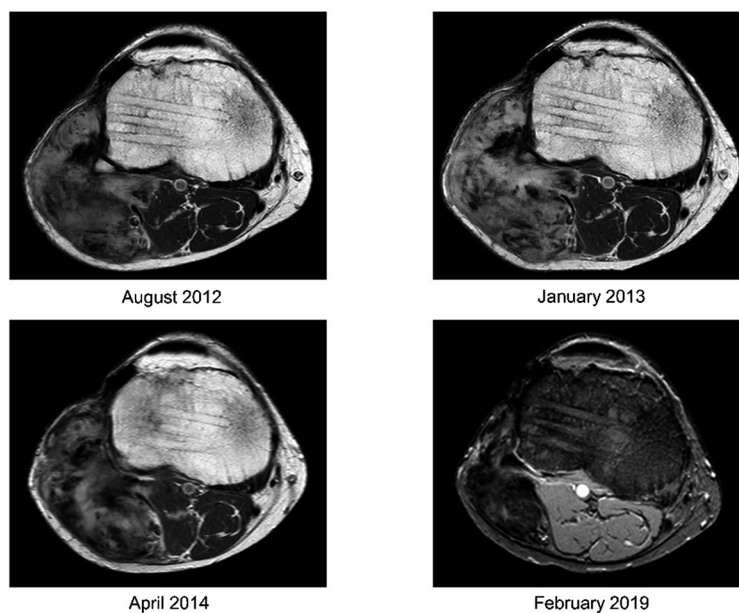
Axial View of a Contrast-Enhanced T1-Weighted Magnetic Resonance Image of a Desmoid-Type Fibromatosis of the Right Knee in a Man Aged 56 Years Demonstrating Evolution Over Time With an Initial Slight Increase in Size, Followed by Stabilization and then Reduction With Symptom Resolution Without Any Treatment.
